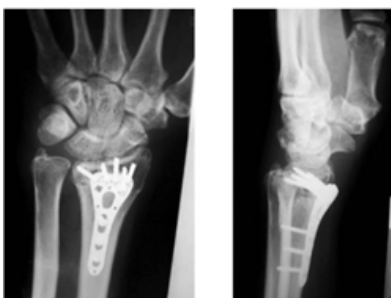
Follow up xray at 6 month
